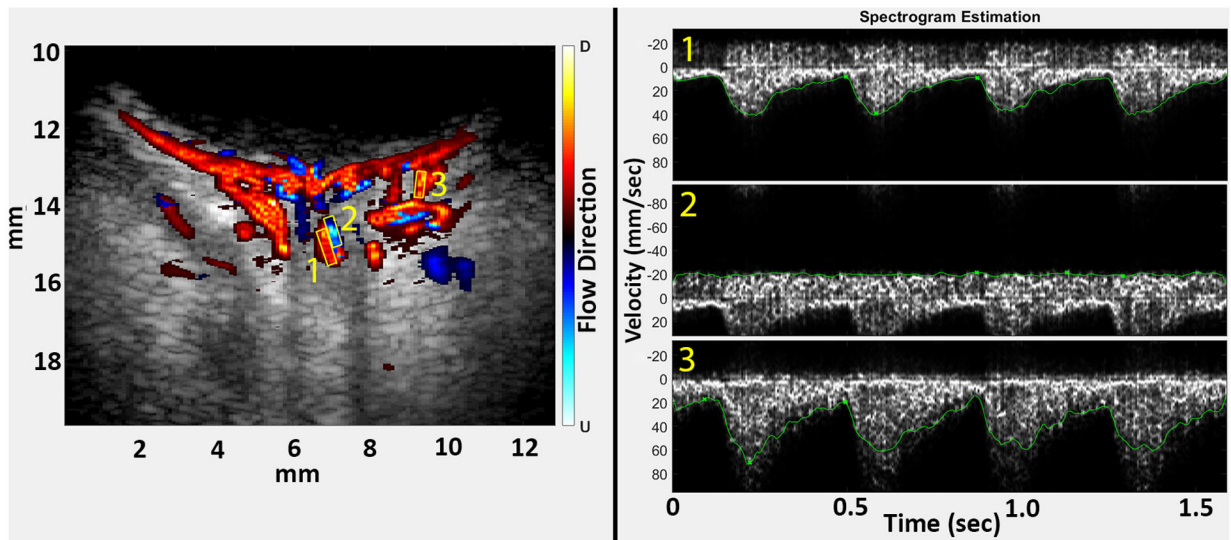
Plane-wave Doppler color flow image and spectrograms of pre-term, low birthweight neonate evaluated at cribside in neonatal intensive care unit. Data were acquired from 6 compounded angled transmits with 3000 compound images acquired per second. Spectrograms depict flow velocity over 1.5 seconds in the central retinal artery (1), central retinal vein (2) and short posterior ciliary artery (3).
